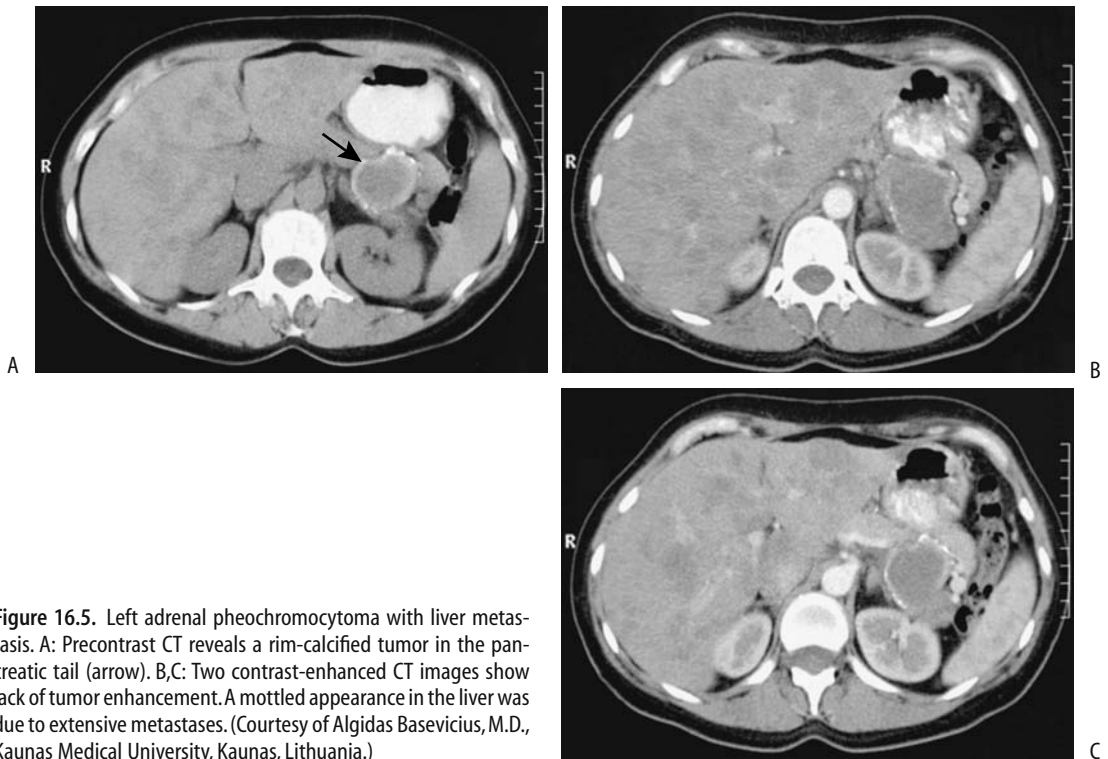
Left adrenal pheochromocytoma with liver metastasis. A: Precontrast CT reveals a rim-calcified tumor in the pancreatic tail (arrow). B,C: Two contrast-enhanced CT images show lack of tumor enhancement. A mottled appearance in the liver was due to extensive metastases. (Courtesy of Algidas Basevicius, M.D., Kaunas Medical University, Kaunas, Lithuania.)
